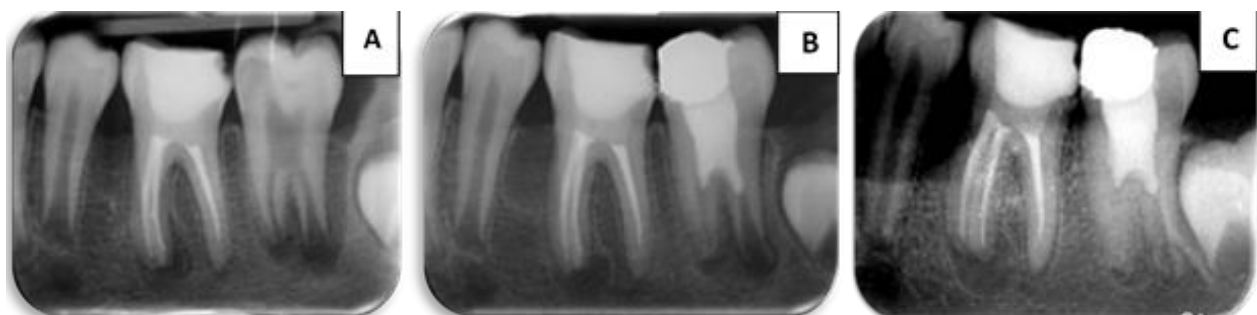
A: Preoperative radiograph; B: radiograph immediately after GPR; C: 1-year follow-up radiograph.
